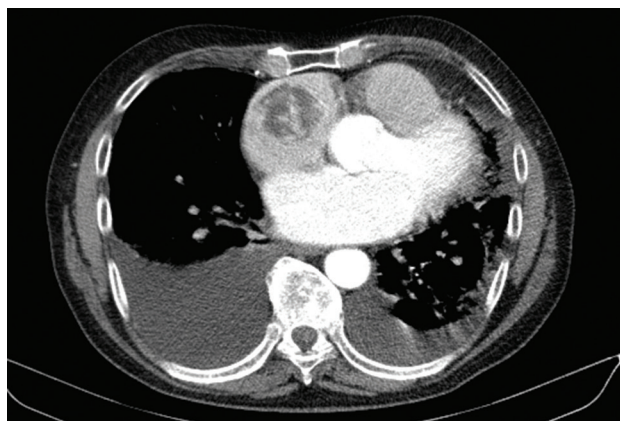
Computed tomography image showing right atrial mass with inhomogeneous structure, suggestive for a myxoma or thrombus.
